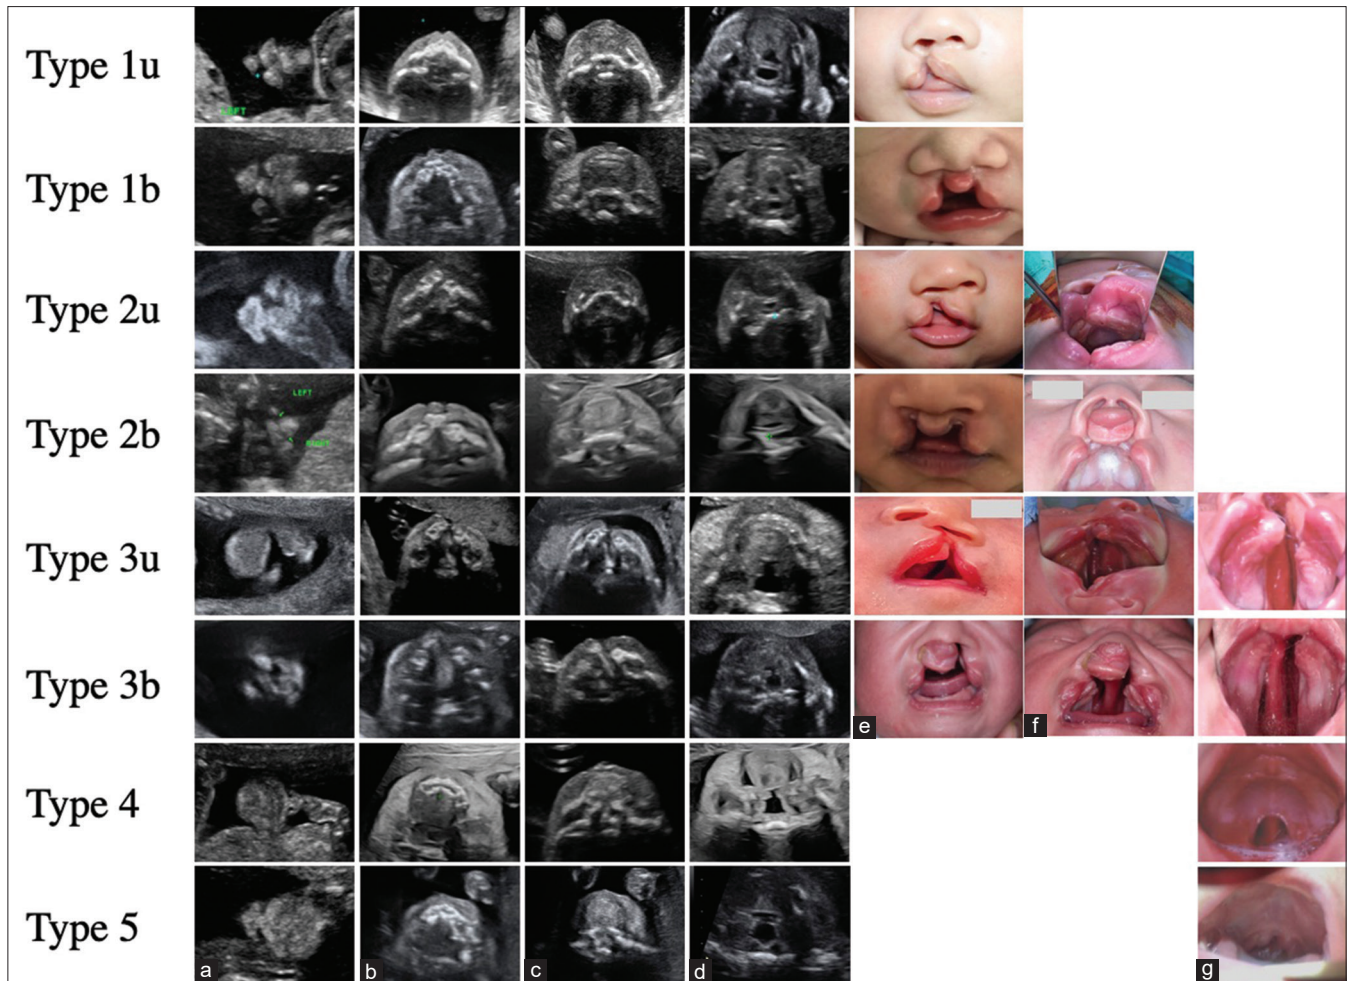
Prenatal 2D ultrasound images of the orofacial clefts according to Maarse *et al.* classification in basic axial view, coronal view, sagittal view, and advanced oblique axial view with corresponding postnatal pictures. Prenatal 2D ultrasound images: (a)-lip; (b)-maxillary alveolus; (c)-posterior edge of hard palate; (d)-posterior part of soft palate. Type 1: A (+) B (-) C (-) D (-) cleft lip with the intact alveolus, hard palate and soft palate. Type 2: A (+) B (+) C (-) D (-) cleft lip and alveolus with the intact hard palate and soft palate. Type 3: A (+) B (+) C (+) D (+) cleft lip, alveolus, and palate. Type 4: A (-) B (-) C (+) D(+), intact lip and alveolus with the cleft hard palate and soft palate during fetal swallowing. Type 5: A (-) B (-) C (+) D (+/-), intact lip, alveolus with disrupted posterior edge of the hard palate and intact mucous membrane of soft palate during fetal swallowing. The corresponding postnatal photographs: (e)-lip; (f)-alveolus; (g)-palate
